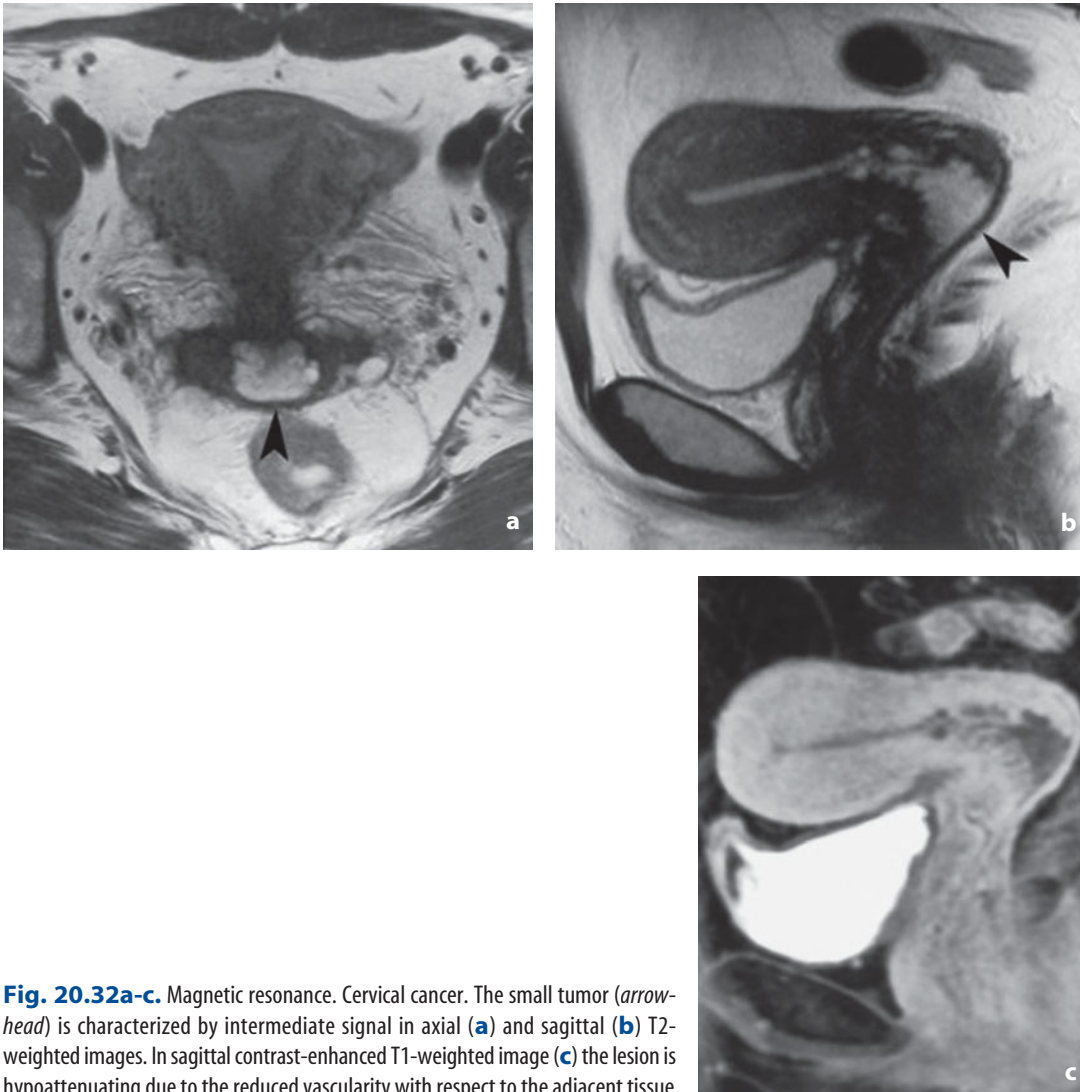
Magnetic resonance. Cervical cancer. The small tumor (*arrowhead*) is characterized by intermediate signal in axial (a) and sagittal (b) T2-weighted images. In sagittal contrast-enhanced T1-weighted image (c) the lesion is hypointense due to the reduced vascularity with respect to the adjacent tissue
